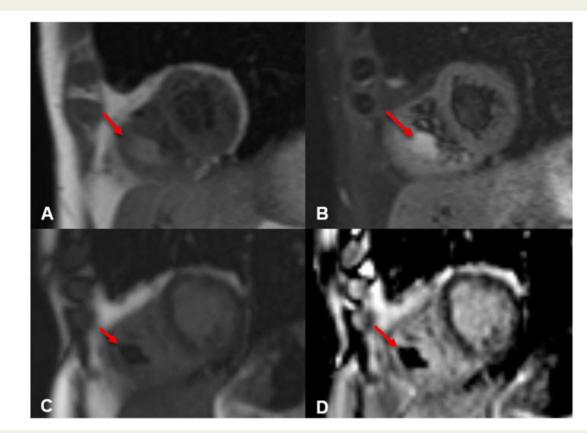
Tissue characterization of right ventricular thrombus: (A) T1-weighted and (B) T2-weighted short-axis view: mural mass with high signal intensity (indicated by the arrow) indicating the recent character of the thrombus. (C) Early gadolinium enhancement and (D) late gadolinium enhancement short-axis view: no uptake of contrast agent in the mass (indicated by the arrow) suggesting no vascularity within the mass.
